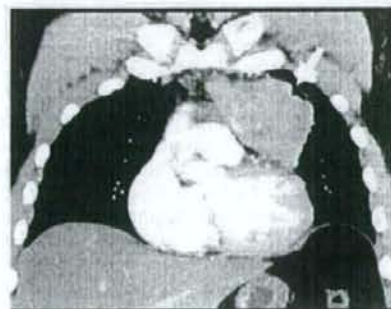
A 40-year-old man with Type B2 and Masaoka stage II. CT revealed that the tumor morphology was similar to that in Fig. 2, but ^{18}F -FDG PET showed that ^{18}F -FDG accumulation in the tumor was more pronounced than that in the mediastinum. The T/M ratio was 3.40.
